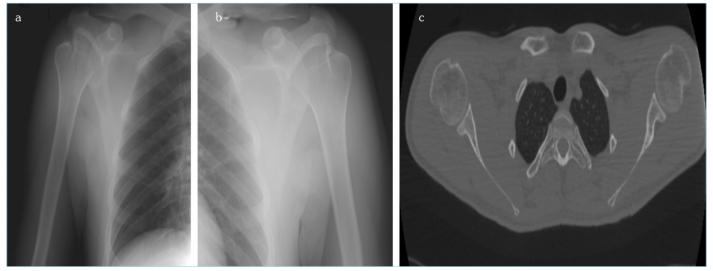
(a) Direct radiography of the right shoulder performed after reduction (b) Direct radiography of the left shoulder performed after reduction (c) CT scan performed after reduction
